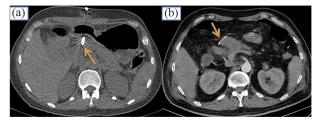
Post surgery CT scan control without contrast (a) and after contrast enhancement (b) showing anastomoses of WHIPPLE surgery: the jejunal loop is anastomosed to the right of the remaining pancreas and to the anterior surface of the superior mesenteric artery (orange arrow).
